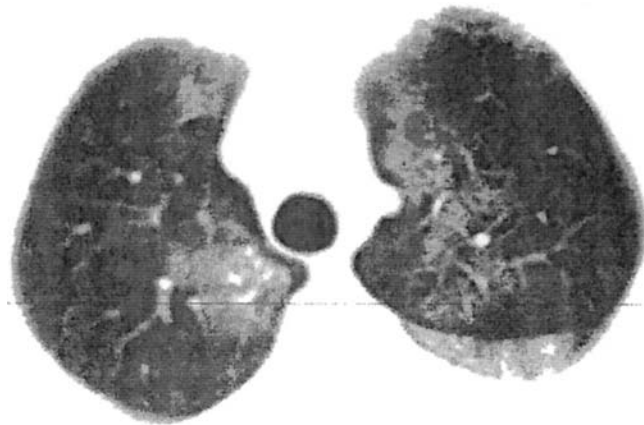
Pulmonary alveolar proteinosis (PAP). Focal, dense ground glass opacities which are well demarcated from adjacent radiographically normal lung parenchyma.
